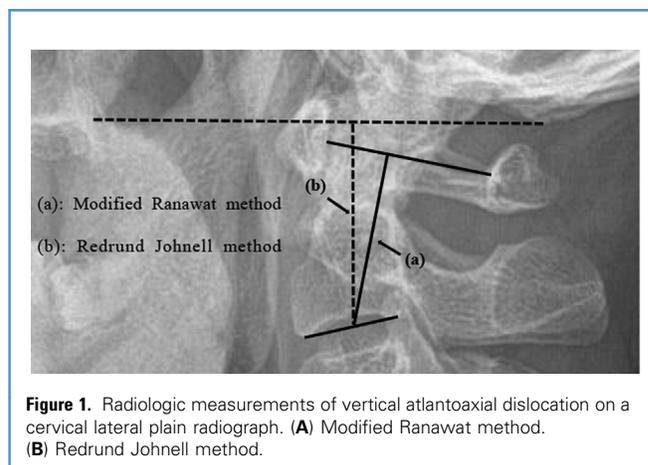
Radiologic measurements of vertical atlantoaxial dislocation on a cervical lateral plain radiograph. (A) Modified Ranawat method. (B) Redlund-Johnell method.
